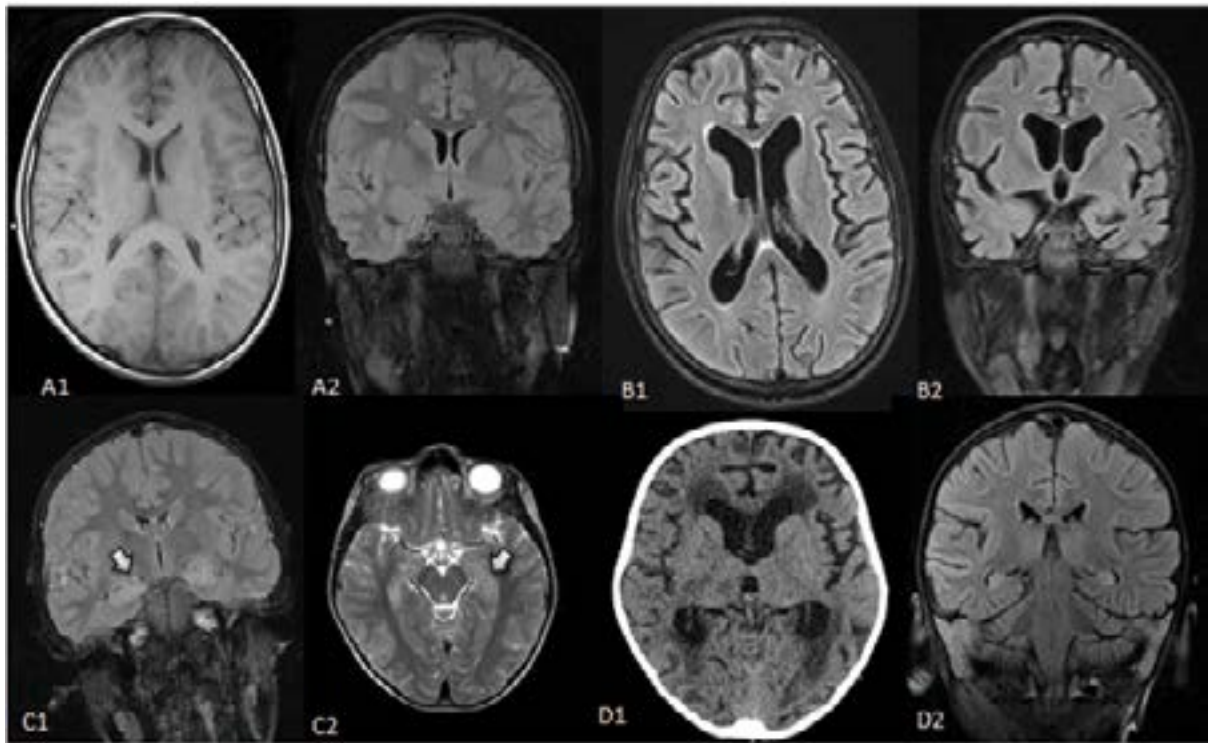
Patient 1: A (A1-axial image, A2-coronal image) Normal MRI in the acute phase of FIRES, B (B1-axial image, B2-coronal image) Moderate diffuse cortical atrophy at the 12 months of follow-up. Patient 2: C (C1-coronal image, C2-axial image) MRI revealed a hyperintensity (arrows) in the bilateral posterior hypothalamic region on a fluid-attenuated inversion recovery (FLAIR) sequence in acute phase, D (D1-axial image, D2-coronal) severe diffuse cortical atrophy at the 12 months of follow-up.
